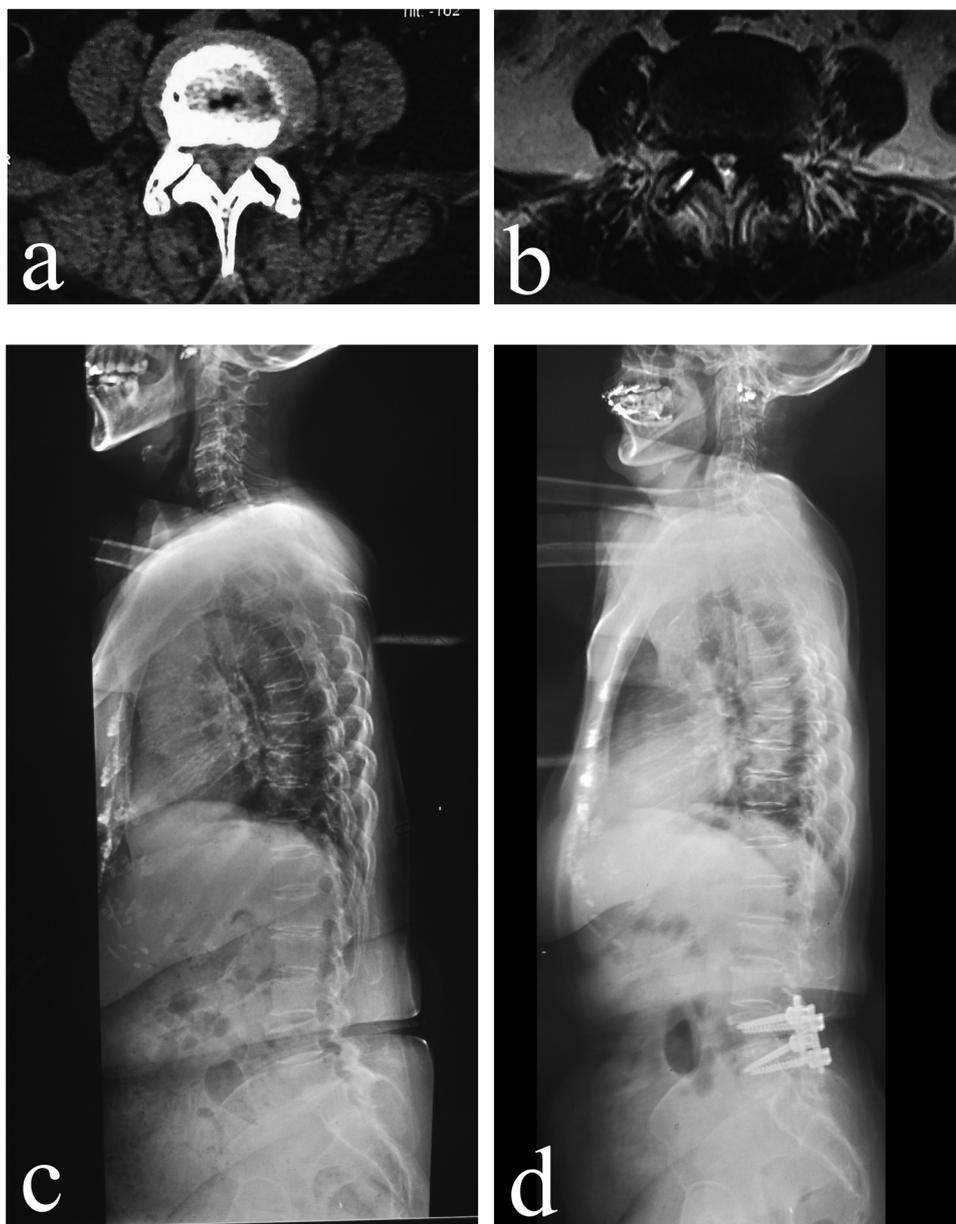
Typical case 3. CT and MRI showed LSS at L4-5 level (a, b). Preoperative radiographs showed sagittal imbalance (SVA = 98.9 mm) (c). Postoperative radiographs showed sagittal imbalance was not restored (SVA = 48.7 mm) at final follow-up (d).
